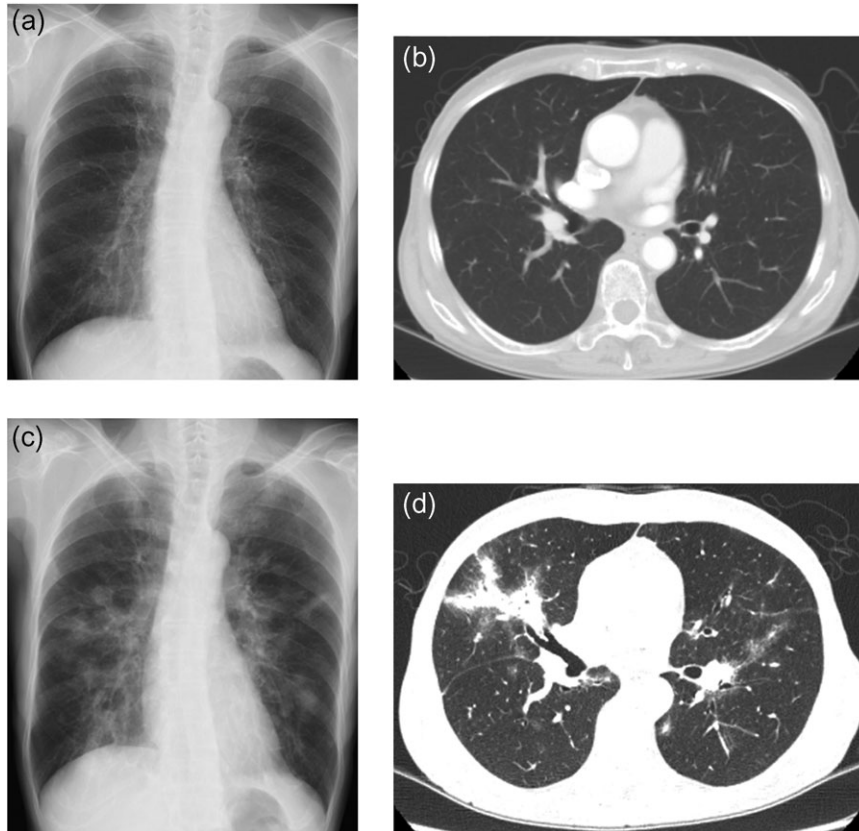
Follow-up chest X-ray and computed tomography (a and b) before treating with nivolumab, (c and d) after 57 cycles of nivolumab treatment. In both lung lobes, ground glass opacities and small coin lesions appeared.
